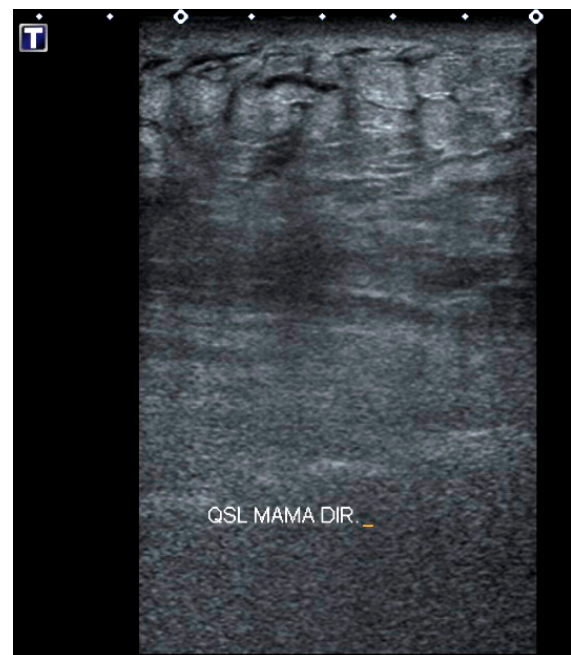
Ultrasonography – cutaneous thickening and hyperechogenicity of the subcutaneous cellular tissue, with anechoic serpiginous images of permeation (edema).
